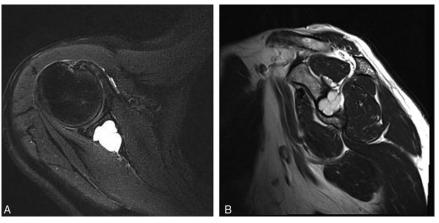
Preoperative magnetic resonance imaging (MRI) of the lesion. (A) The lesion shows high signal intensity on fat-suppressed T2-weighted axial imaging. The suprascapular nerve is compressed by the intraosseous lesion through a cortical defect in the posterosuperior area of the glenoid. (B) The cystic lesion within the glenoid was multilobulated on T2-weighted turbo spin echo sagittal imaging.
